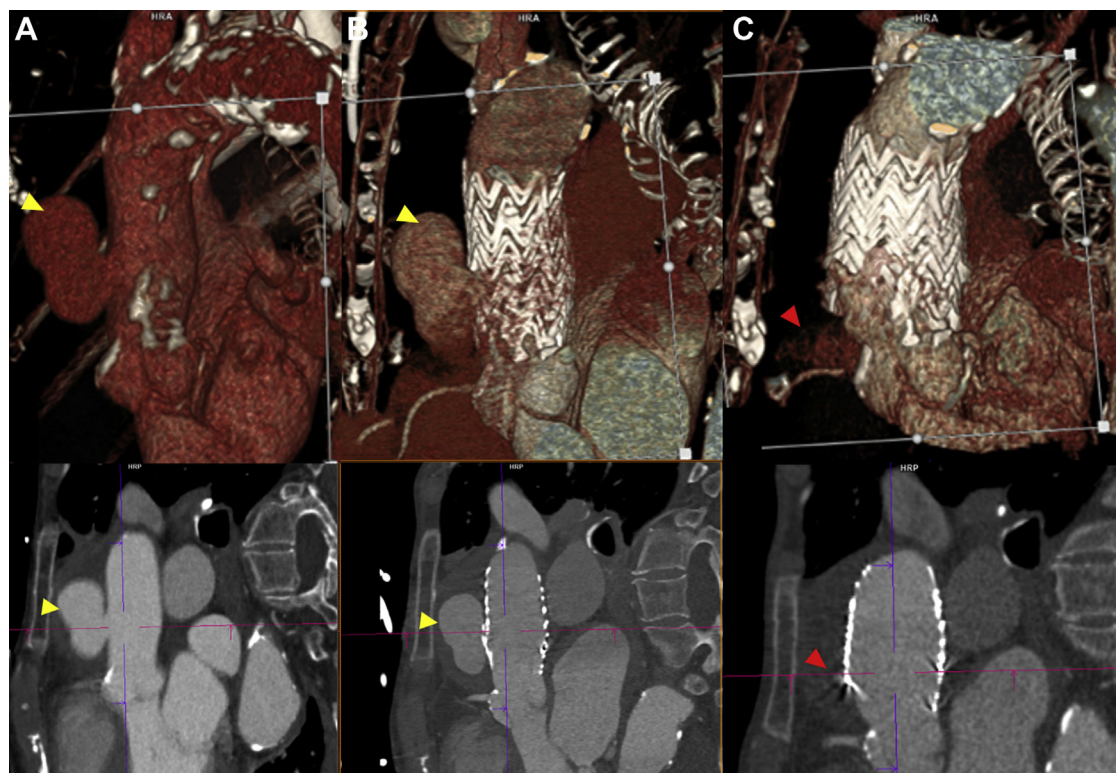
Type IA endoleak after graft deployment. Computed tomography angiography (CTA) (oblique sagittal and volume-rendered views) showing ascending aortic pseudoaneurysm (yellow arrow) before aortic stent graft placement (A) and after aortic stent graft placement (B). After ballooning and additional stent graft deployment (C), a type IA endoleak (red arrow) of the ascending aortic graft after graft deployment was noted, although no residual endoleak was appreciated initially by angiography.
